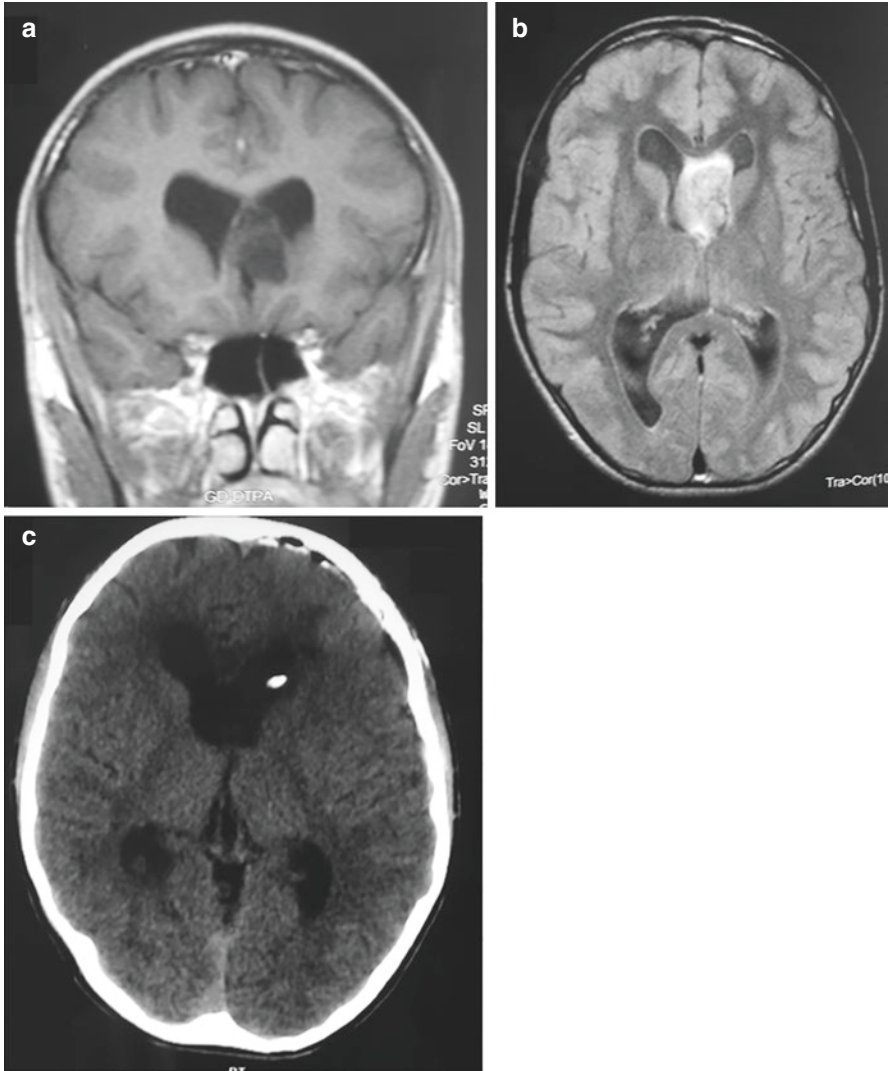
A case of a 12-year-old boy with intractable epilepsy. MRI revealed an intraventricular mass that exhibited no enhancement after gadolinium administration (a). Increased signal intensity in FLAIR sequences was observed (b). The patient was operated on via a left frontal transcortical approach to the tumor and the lesion was totally excised (c). Pathology revealed the presence of a DNET. The Ki-67/MIB-1 index was 1–2%
